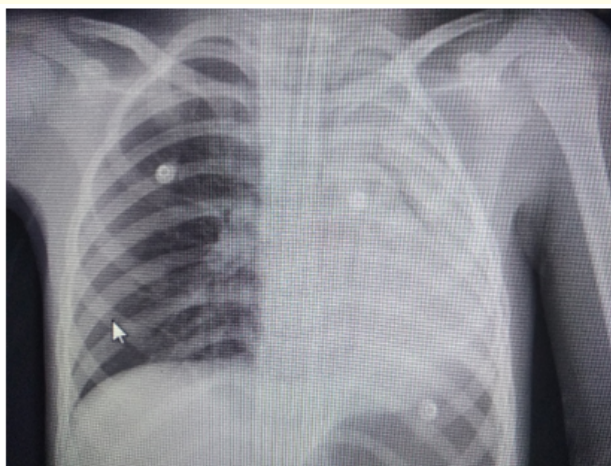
Chest radiograph showing left-sided opacification.
